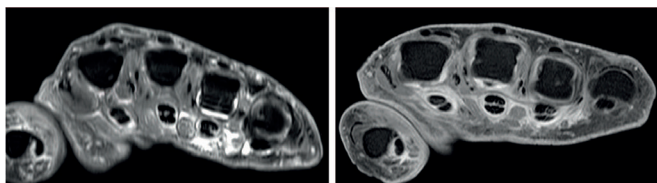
Example of synovitis and tenosynovitis in the MCP joints and flexor tendons depicted with a modified Dixon sequence and conventional sequence on a 1.5 T extremity MRI scanner of one patient. Legend: left; water-only axial reconstruction of a modified Dixon sequence. Right; axial T2 weighted image of a 1.5 T extremity MRI scanner with contrast agent. Images are made in the same patient. MCP 3 and 4 are scored for synovitis. Tenosynovitis is scored in the flexor tendons of fingers 2, 3 and 4. MCP, metacarpophalangeal.
